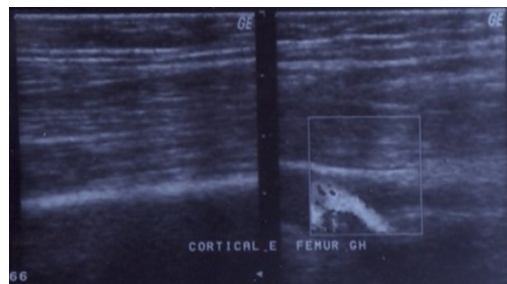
Ultrasonography and Doppler of the soft parts of the thigh- thickening of the cortical bone of the left femur.
